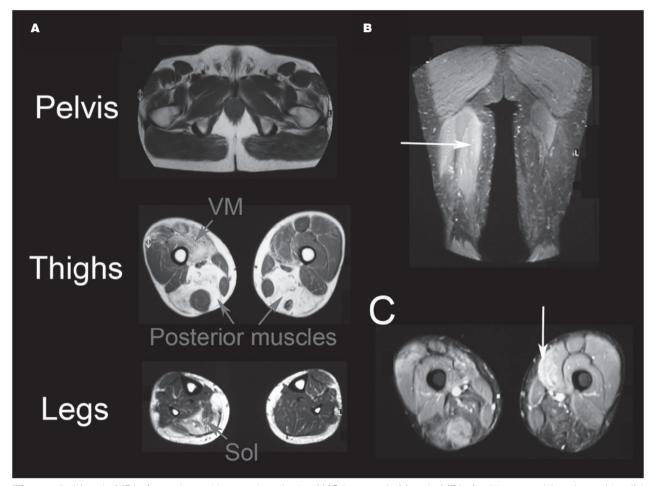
Muscle MRI of a patient with mutations in the ANO5 gene. A: Muscle MRI of a 53 years old patient with mild involvement of the lower limbs. Axial images showed no involvement of pelvic muscles, but in contrast there was a clear asymmetric involvement of vastus lateralis (VL) and posterior muscles of the thighs. In the legs, muscles of the posterior compartment were also involved, including soleus (Sol) and gastrocnemius medialis. B and C: hypenintensities in STIR sequences were observed in the posterior muscles of the thighs and in the vastus medialis muscle (arrows).
